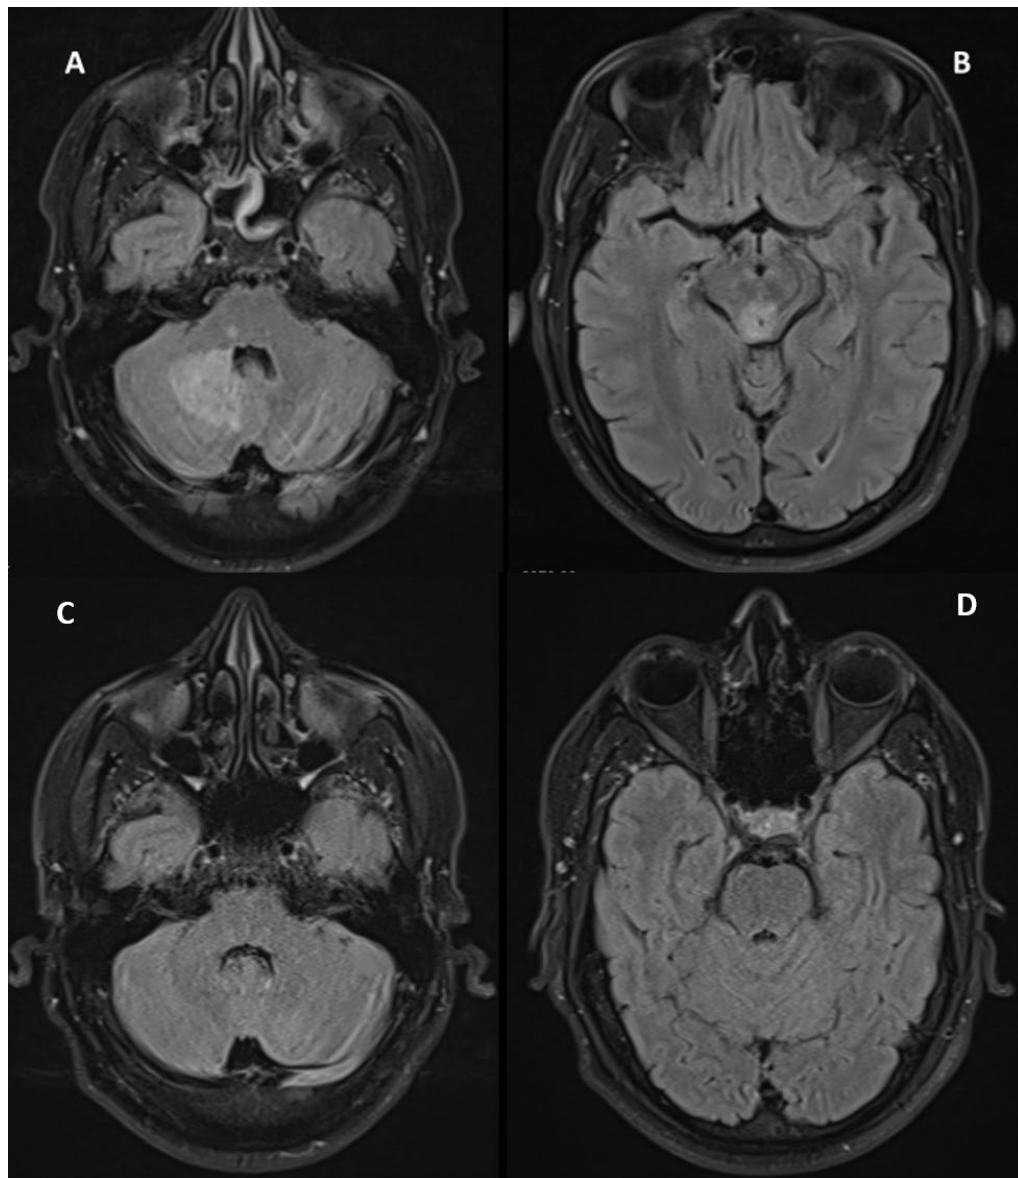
MRI findings of a 17-year-old patient with recurrent diplopia. (A, B) Initial brain MRI reveals diffuse hyperintensity in the peri-aqueductal region, pons, and cerebellum. (C, D) Follow-up MRI demonstrates complete resolution of these lesions after treatment.
